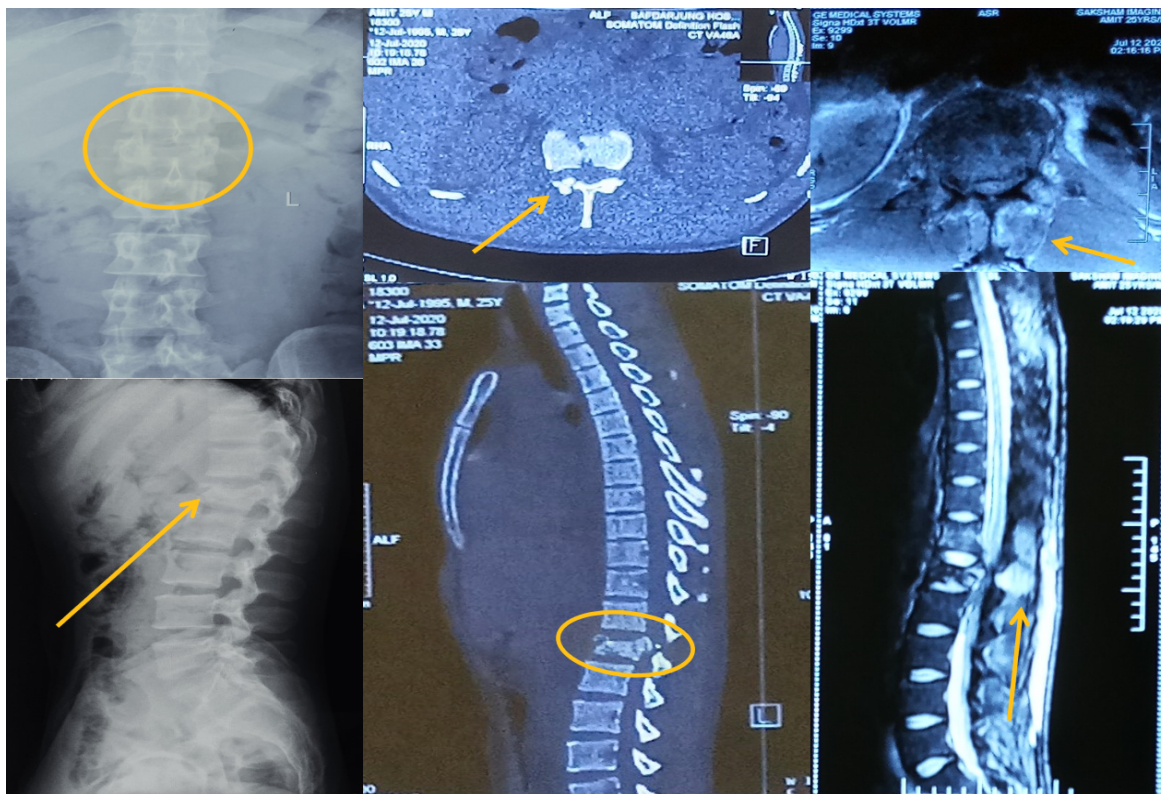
(Case 1)A 24/M with traumatic spine injury showing compression fracture of L1 vertebrae (LOVBH= 44%, LK=25°) showing no any evidence of PLC injury on plain radiograph but on subsequent CT and MRI shows signs of PLC injury.
